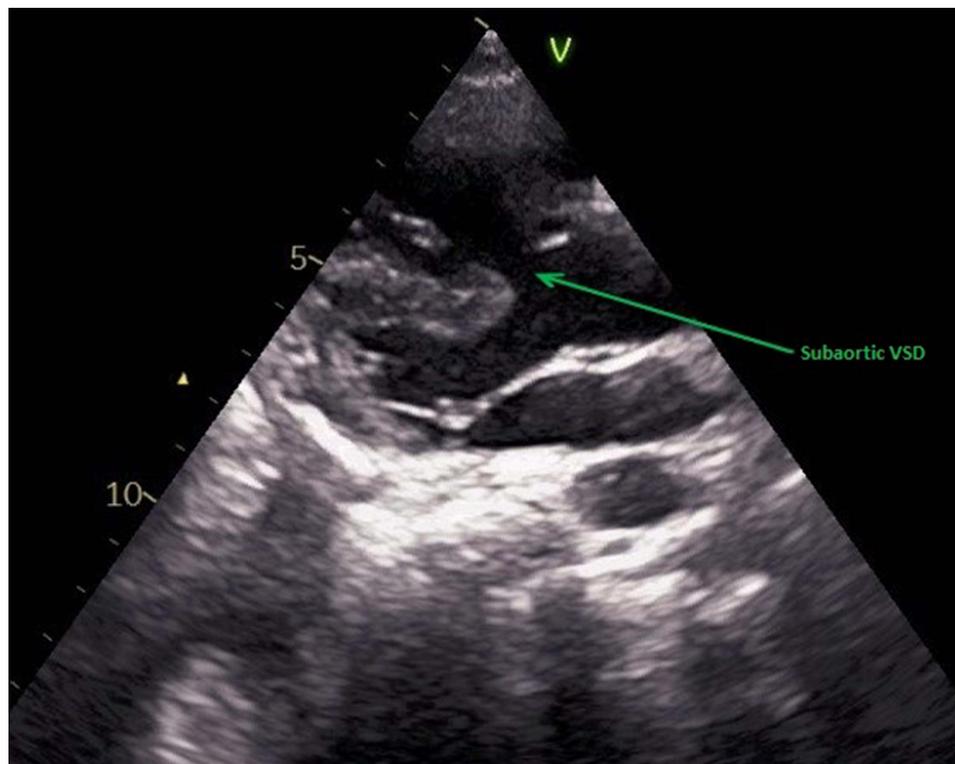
Echocardiography showing large subaortic VSD.
